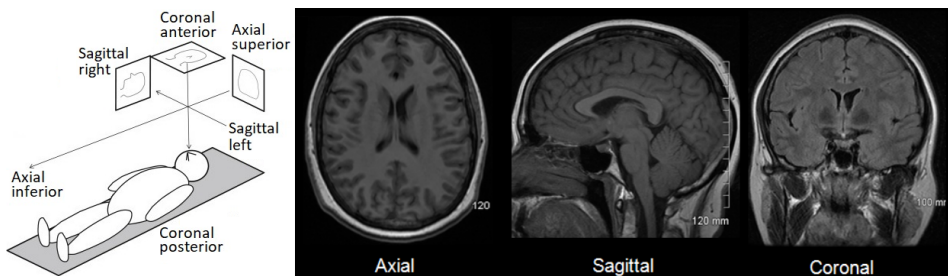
MRI slices of the axial, sagittal, and coronal planes [129]
